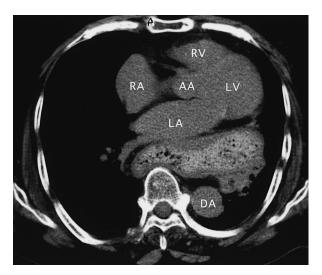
Cross-sectional spiral computed tomography scan
